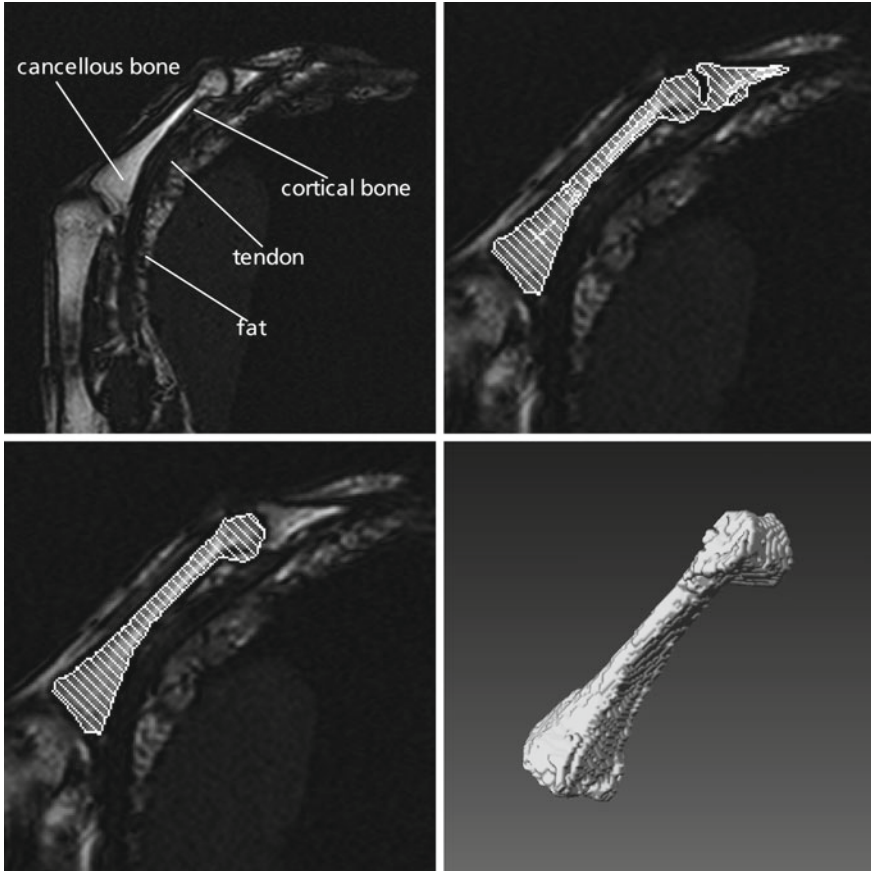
Segmentation process. *Top left*: Slice of an MRI image, showing the middle finger metacarpal (MC3). Tissue types can be discriminated by the intensity of the signal that is emitted. Segmentation is done at the boundary between cancellous and cortical bone. *Top right*: Threshold-based preselection. *Bottom left*: Manually refined selection. *Bottom right*: Segmented volume consisting of the selected areas from all slices
